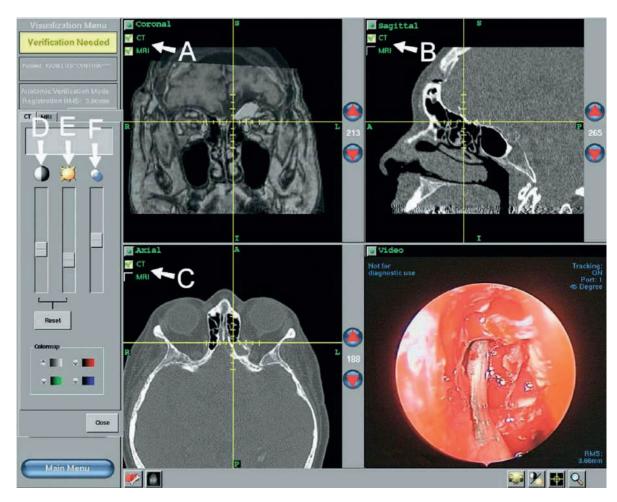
This intraoperative image capture demonstrates the typical screen view. *Top left panel*: fused CT-MR image. *Top right, bottom left panels*: pure CT images. It is possible to select CT, MR, CT-MR fusion images directly (through toggle-type switches), or one may 'morph' between CT and MR images (through a slider-type control). *A-C*) Toggles for choosing between CT, MR and CT-MR fusion images. (*D*) Slider for image contrast. (*E*) Slider for image brightness. (*F*) Slider for CT-MR fusion control. From: Leong JL, Otolaryngol Head Neck Surg 2006; 134:868–876
